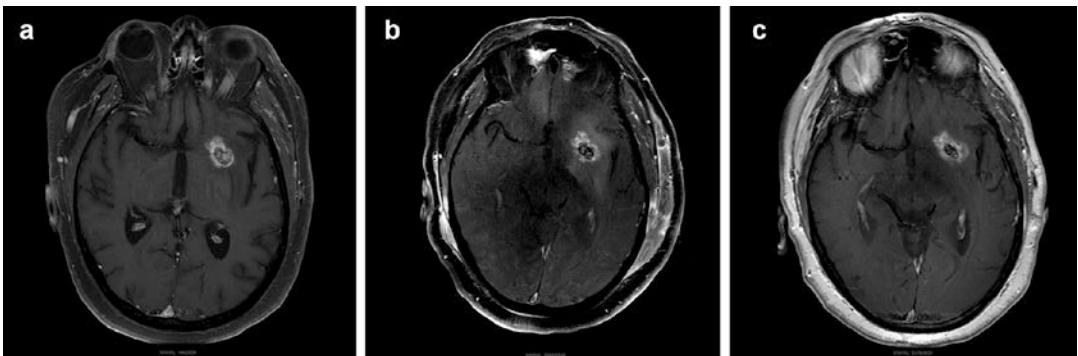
T1-weighted post-contrast MR images showing a metastatic lesion preceding LITT (a), immediately after LITT (b), and at one-month follow-up (c)
